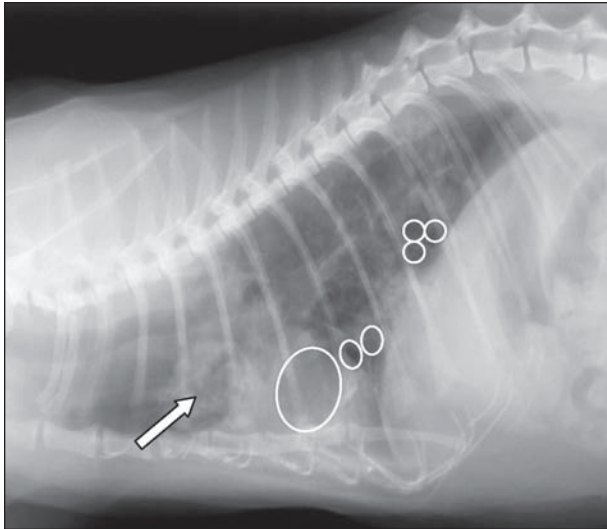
Same lateral radiographic view as in Figure 1. Notice multiple smooth thin-walled bullae of various sizes throughout the lungs (circles) and an alveolar pattern (arrow).
